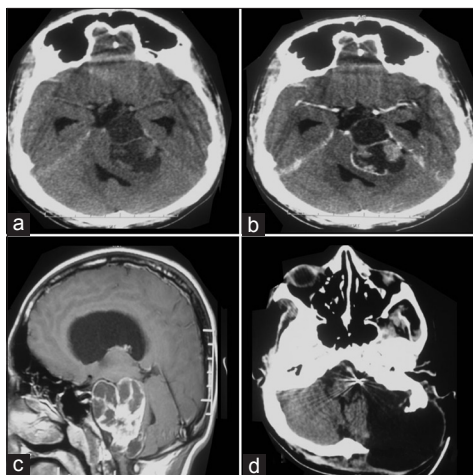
Piccirillo type A3 cystic VS. non-contrast CT (a) demonstrating a hypodense lesion in the right cerebellopontine angle with hyperdensity, suggestive of bleed within the tumor. Post-contrast CT (b) done after six years did not reveal any tumor recurrence
